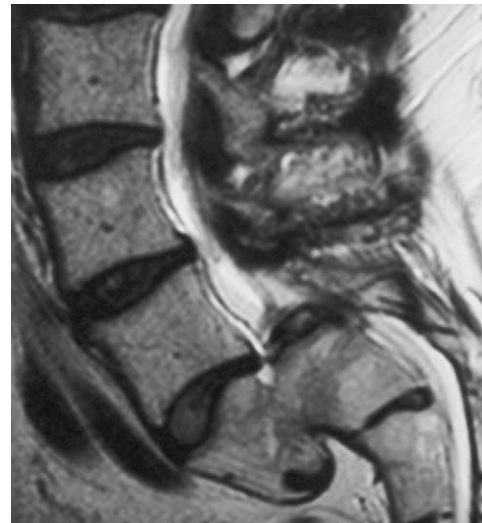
Sagittal T1-weighted MRI of the lumbar spine demonstrating L5 nerve root impingement and the anterior displacement of L5 vertebrae relative to S1.
